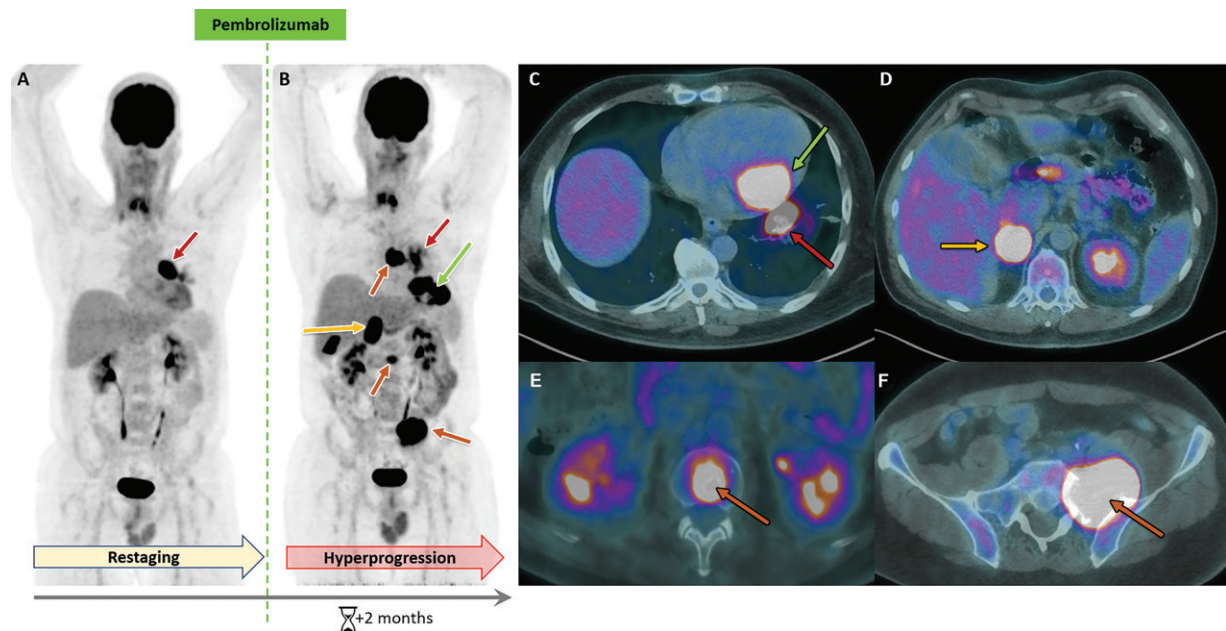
Hyperprogression after immunotherapy in a 50-year-old man with oropharyngeal squamous cell carcinoma. *A*, MIP FDG PET image from the restaging study shows a pulmonary metastasis (arrow). *B–F*, MIP FDG PET (*B*) and axial FDG PET/CT (*C–F*) images after pembrolizumab therapy show hyperprogression, with appearance of metastatic pulmonary (red arrows), heart (green arrows), right adrenal (yellow arrows), and bone (orange arrows) lesions. The patient died 7 months later.
